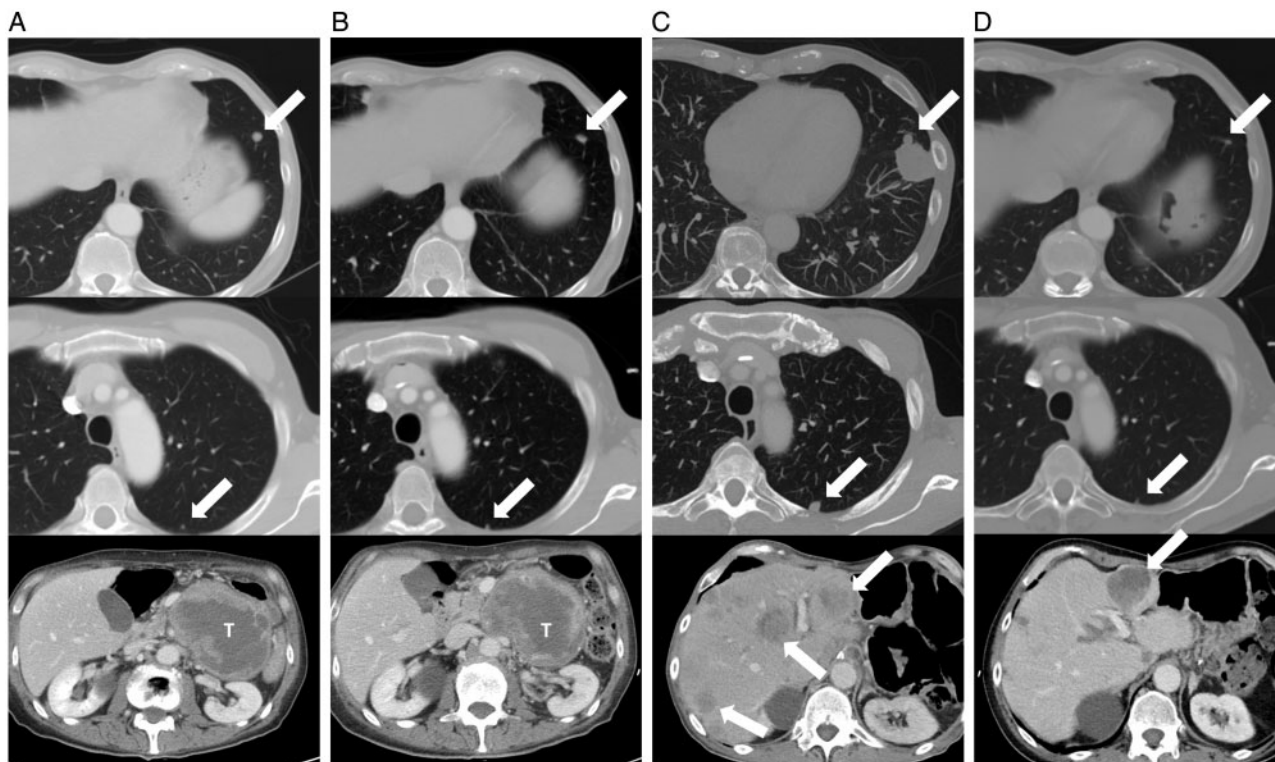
A 66 year-old patient presented with a primary localized 10cm grade 2 leiomyosarcoma of the left retroperitoneum and was scheduled for surgery. Preoperative triphasic CT scan (A) performed one month after initial imaging revealed two synchronous pulmonary metastases (12mm in the left lower lobe and 4mm in the left upper lobe, arrows) and progression of the abdominal mass (10cm to 12cm, T). The patient was treated with upfront Adriamycin + Dacarbazine (DTIC). After two courses the abdominal mass and major lung nodule were stable while the minor lung nodule showed mild progression (4mm to 6mm). The chemotherapy regimen was altered to Gemcitabine 900 mg/m² + DTIC 750 mg/m² and after 5 courses the CT scan (B) showed partial response of the lung nodules (12mm to 8mm, 6mm to 3mm, arrows) and stable disease of the primary tumor. The patient then underwent resection of the primary tumor en bloc with the pancreatic tail, spleen, duodenojejunal flexure and part of the portal vein. Two months after surgery the CT scan (C) showed dimensional and numerical progression of the lung nodules and appearance of bilateral liver metastases. Gemcitabine + Vinorelbine were started with major response in the lungs and partial response in the liver. Eighteen months after the first course of Gemcitabine (D) the lung disease burden was limited and, due to the progression of a single liver nodule, the patient was treated with transarterial chemoembolization with Adriamycin. Twenty-seven months after disease onset the patient is alive with limited disease in the lungs and stable liver metastases.
